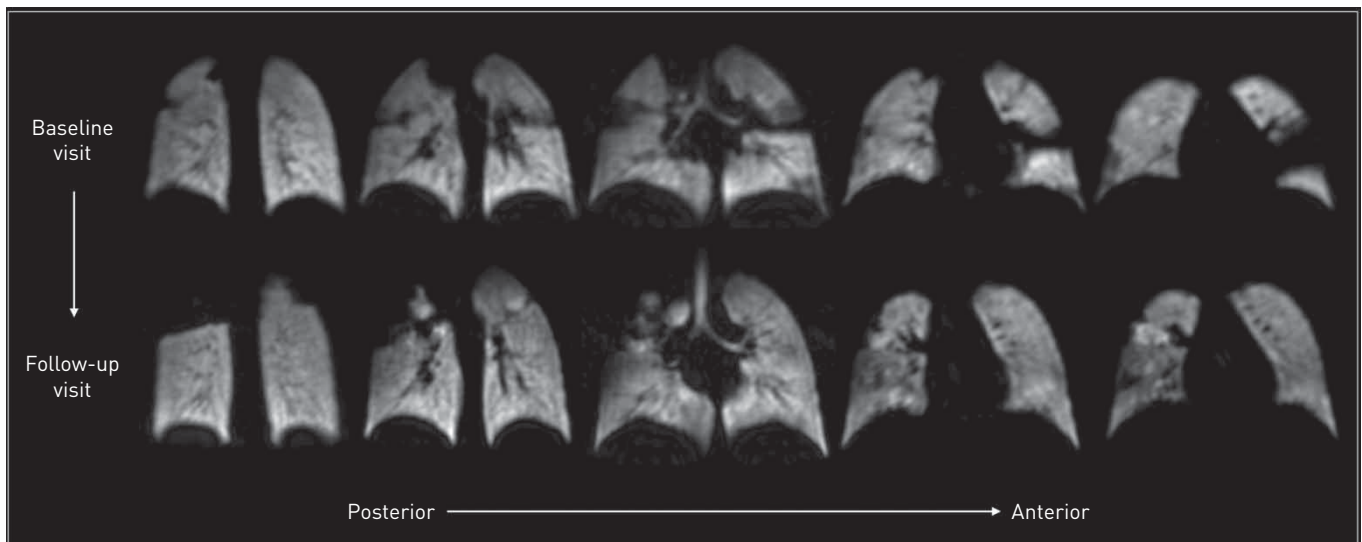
Longitudinal xenon-129 magnetic resonance imaging in a patient with normal forced expiratory volume in 1 s (FEV₁) and lung clearance index (LCI). At follow-up there was a change in VDP from 5.4% to 6.7%. At follow-up, this patient's FEV₁ and LCI were similar to baseline, FEV₁ z-score changed from -0.7 to -1.1 and LCI changed from 6.7 to 7.0. The longitudinal ventilation change in this patient differs between the two lungs. The ventilation defects in the left lung have disappeared and lung disease appears to have improved over time. In contrast, the right lung shows a significant increase/worsening in the degree of ventilation abnormalities present over time. This example highlights the importance of utilising both the qualitative and quantitative image information together and the potential for analysing regional lung disease.
